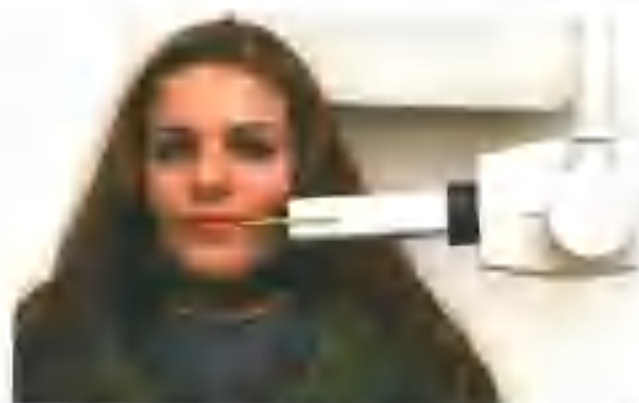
A bitewing radiograph is being taken. A film holder supports the film lingually and the patient closes together on a part of this holder. A beam-aiming device helps the operator to position the tube so that the beam is directed at right angles to the film.
